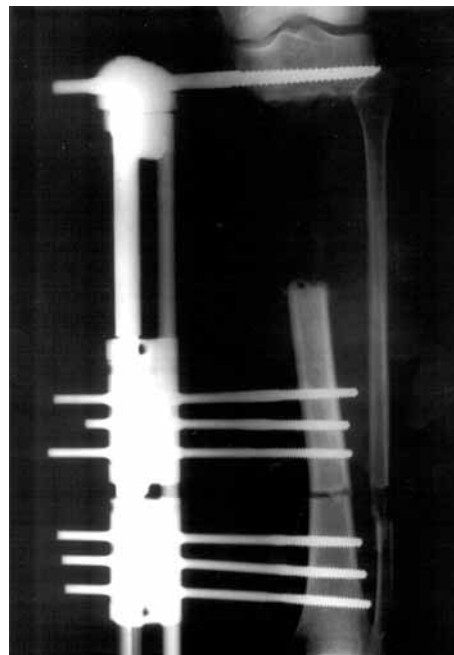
Postoperative radiograph showing the size of the osseous gap and the site of the distal osteotomy performed; application of the LRS (Orthofix) external fixator.
